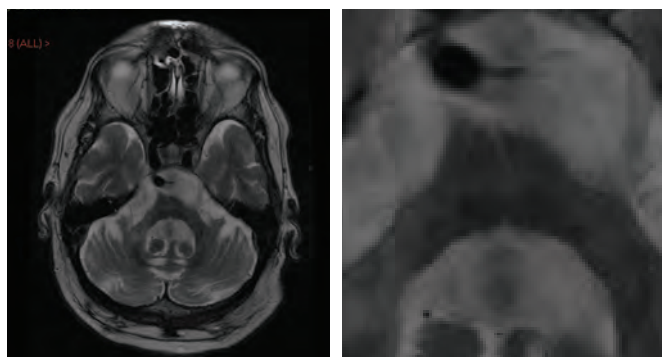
These MRI images demonstrate marked pontine and cerebellar atrophy in a patient with cerebellar variant of multiple systems atrophy. The 'hot cross bun sign' can be seen on the right image.
